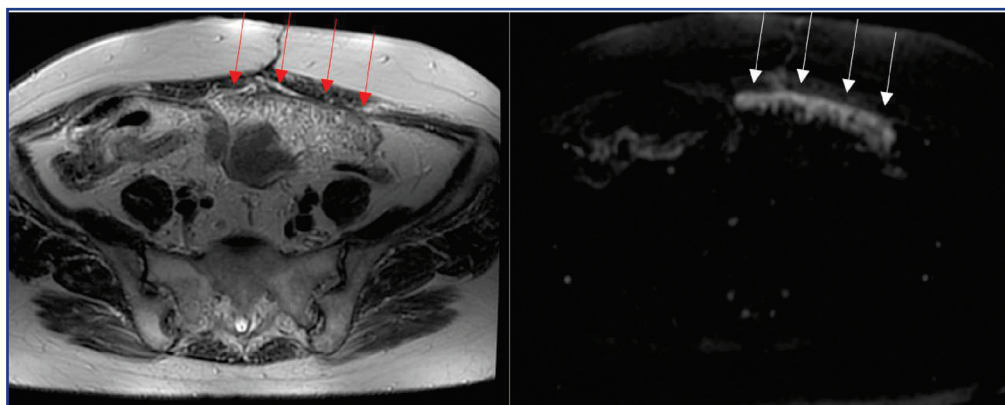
Axial pelvic MRI: Signs of peritoneal carcinomatosis. The T2-weighted image (left) and diffusion-weighted image (right) reveal irregular thickening and nodularity along the peritoneal surfaces (arrows), consistent with metastatic peritoneal involvement
